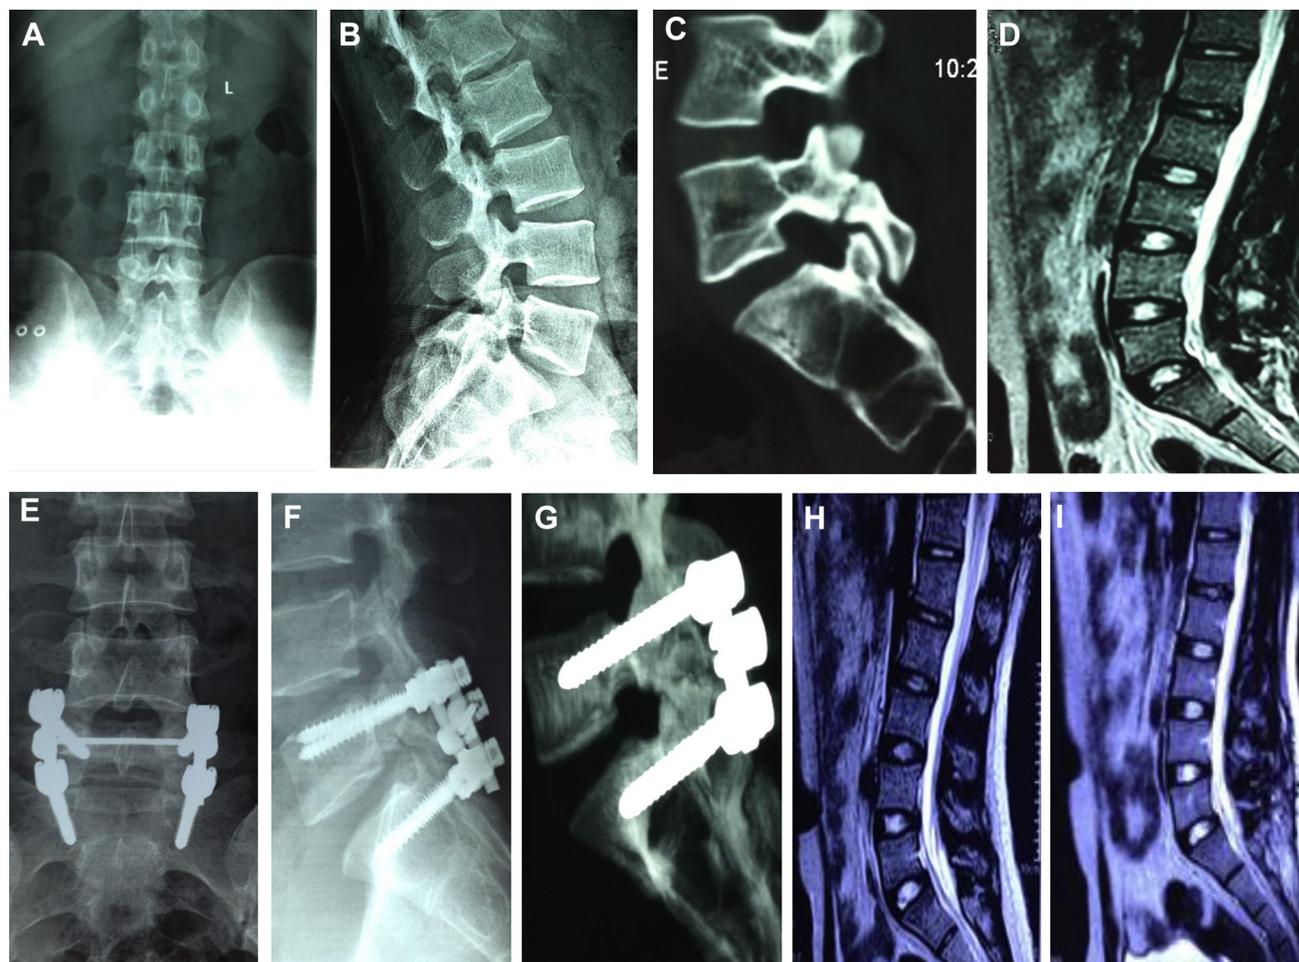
Imaging studies of patient 2. (A–D) Preoperative imaging studies of L5 spondylolysis. (E–G) Postoperative imaging studies. (D, H) Preoperative magnetic resonance imaging studies of patients with isthmus were performed that included the anterior L5-S1 stage; the final plate of the sacral 1 was modified by Modic 3 changes, and the Pfirrmann grade of the L5 sacral vertebra was 1. (I) Postoperative magnetic resonance image
